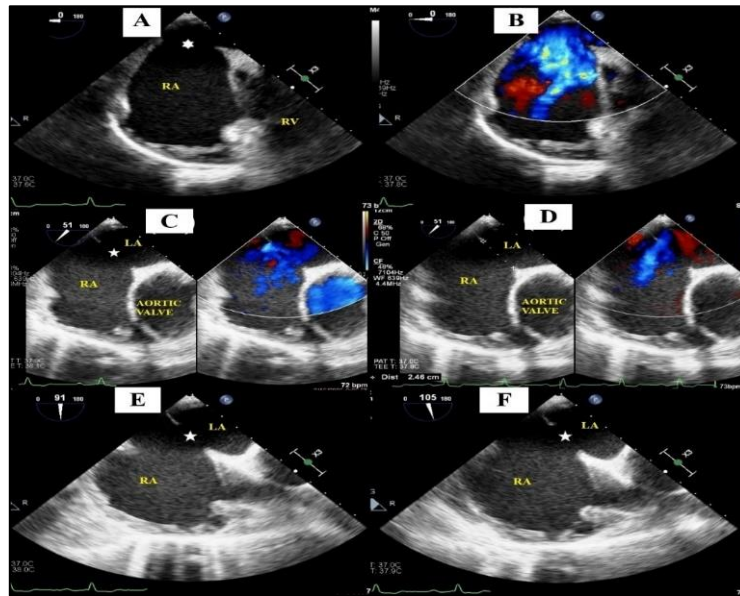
Transesophageal echocardiographic images at 0, 50 and 90-100 degrees showing large ostium secundum atrial septal defect (white star) with left to right shunt. Deficient superior and aortic rim with borderline atrioventricular rim noted (A-D). Superior vena caval and inferior vena caval rims are adequate (E,F). LA- Left atrium, RA- Right atrium
